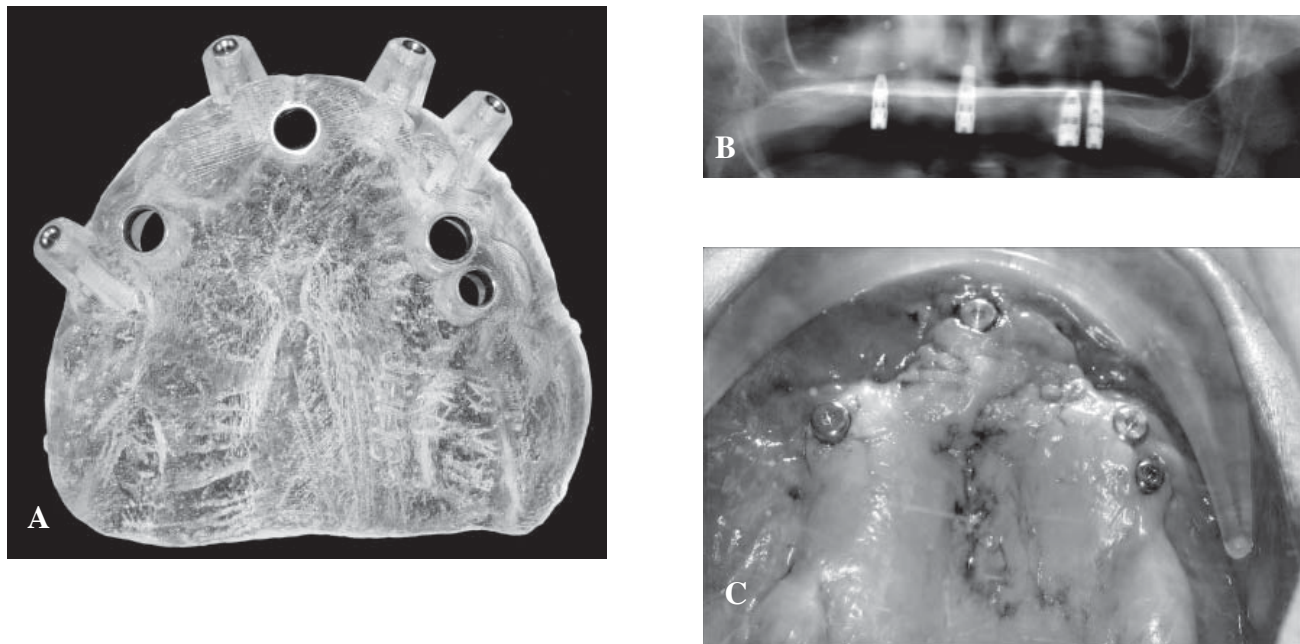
A. NobelGuide™ fabricated from the virtual treatment plan, B. Implant placement in the maxilla, C. Postoperative radiograph with implants in place.
